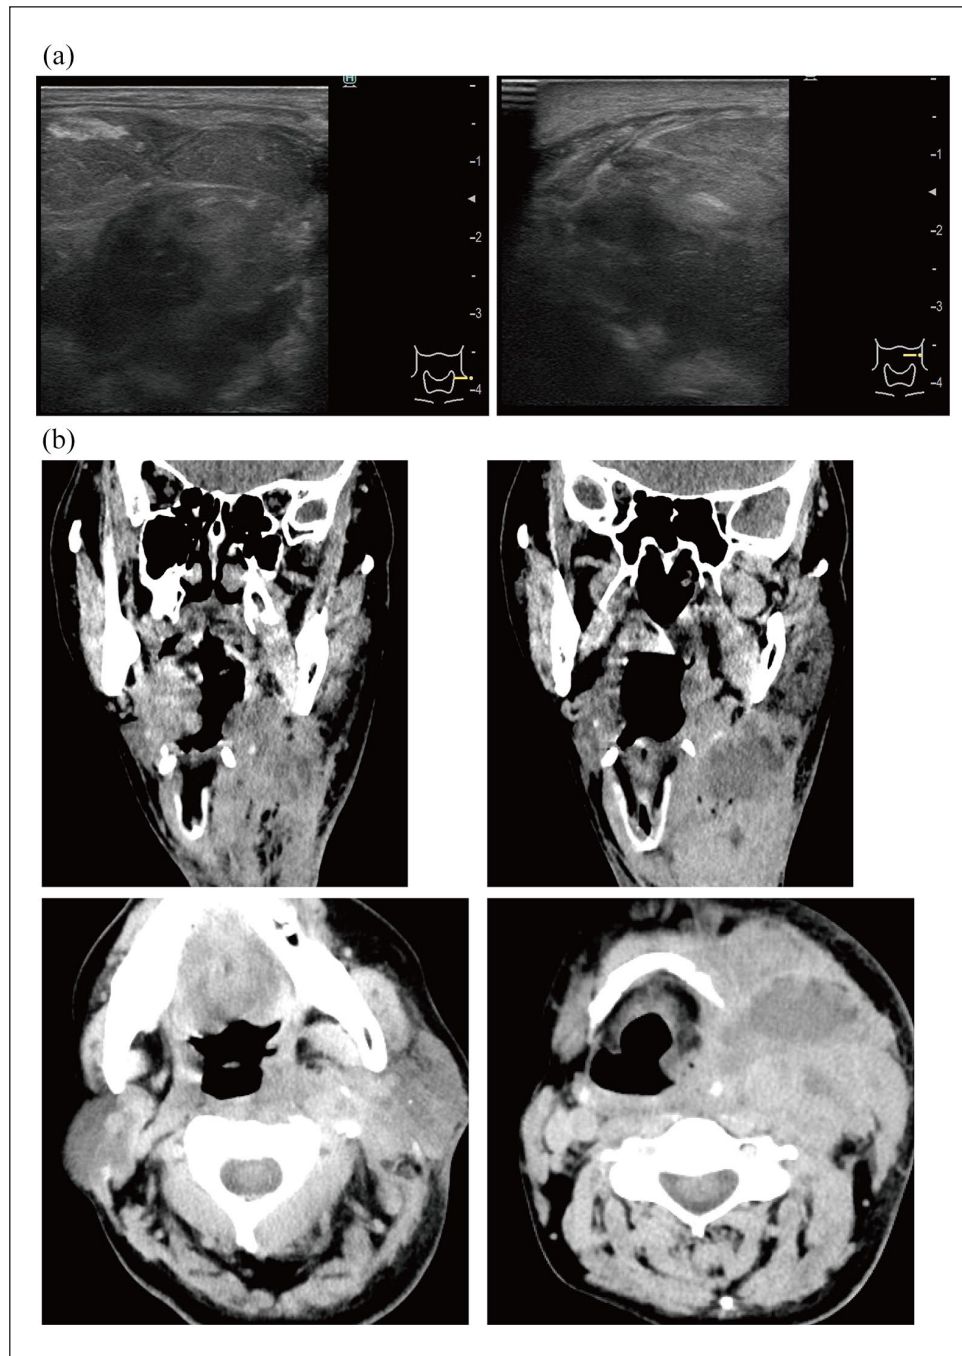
(a) Pre-operative cervical ultrasound image. Extensive hypoechoic areas with indistinct borders noted in the left mandible and just below the sternocleidomastoid muscle in the left neck. (b) Pre-operative contrast-enhanced computed tomography. A low-density area is seen from the left mandible to the left deep neck. The same area has a contrast effect on the margins and an internal septum.
